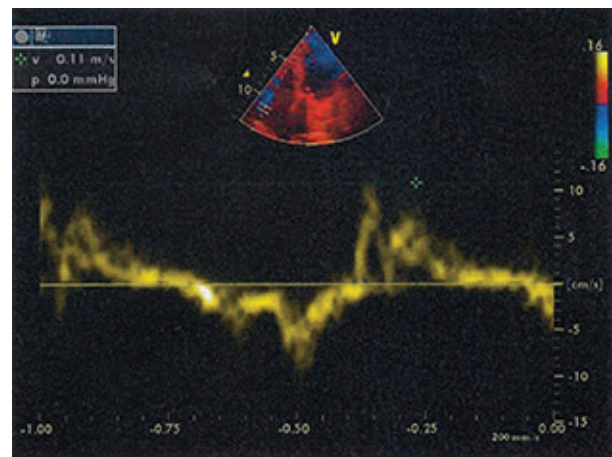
Tissue Doppler study of right ventricular function after surgery in the same patient with subvalvular apparatus preservation during MVR. There was no change in S prime and IVA before and after surgery.
